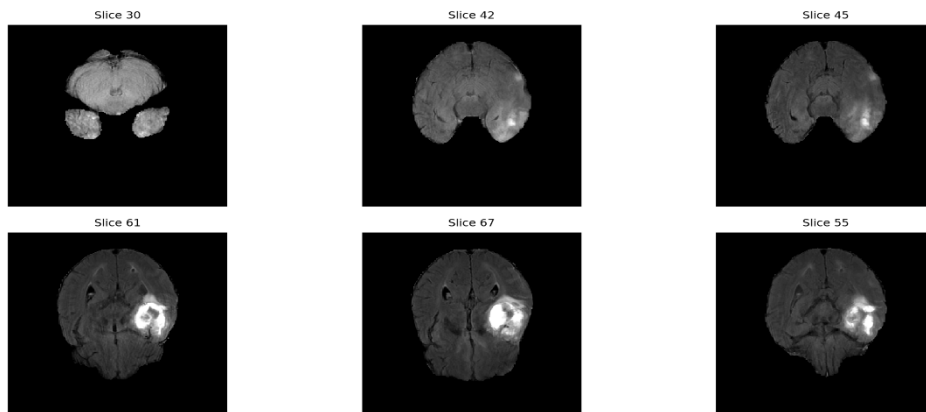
Example of FLAIR MRI slices from the BraTS 2023 dataset, with different cross-sections of the brain.
